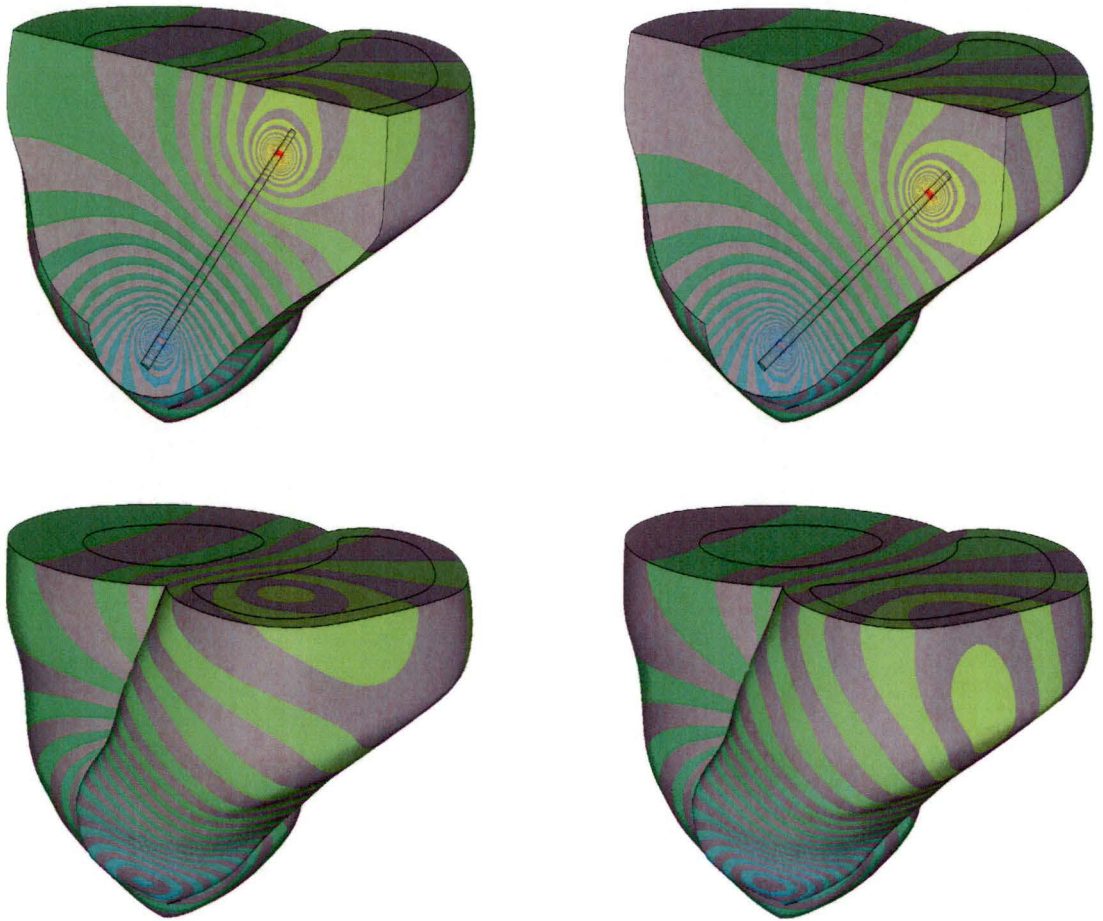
Off centre (septum - free wall direction) right ventricle catheter voltage contours in tagged MRI model at end systole for blood conductivity/myocardium conductivity = 2.75.
